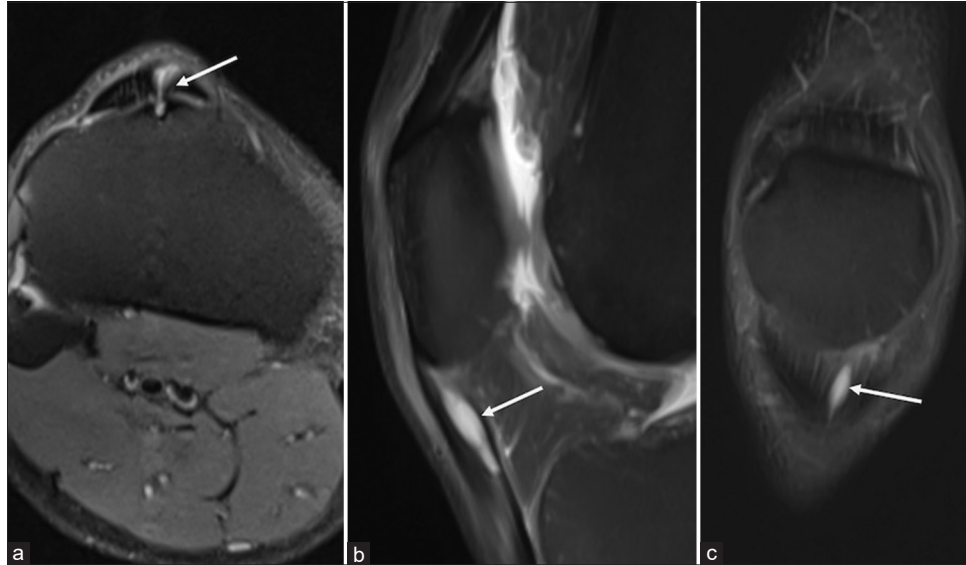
(a) Axial, (b) sagittal, and (c) coronal proton-density fat-saturated (PDFS) images of magnetic resonance imaging knee at the level of cyst show a well-defined PDFS fluid intensity oval-shaped lesion noted just distal to the inferior pole of the patella in the patellar tendon (White arrow). The cyst has caused mild local expansion of the patellar tendon, resulting in a focal fusiform enlargement. Note the partial tear of a few fibers of the patellar tendon (White arrow).
